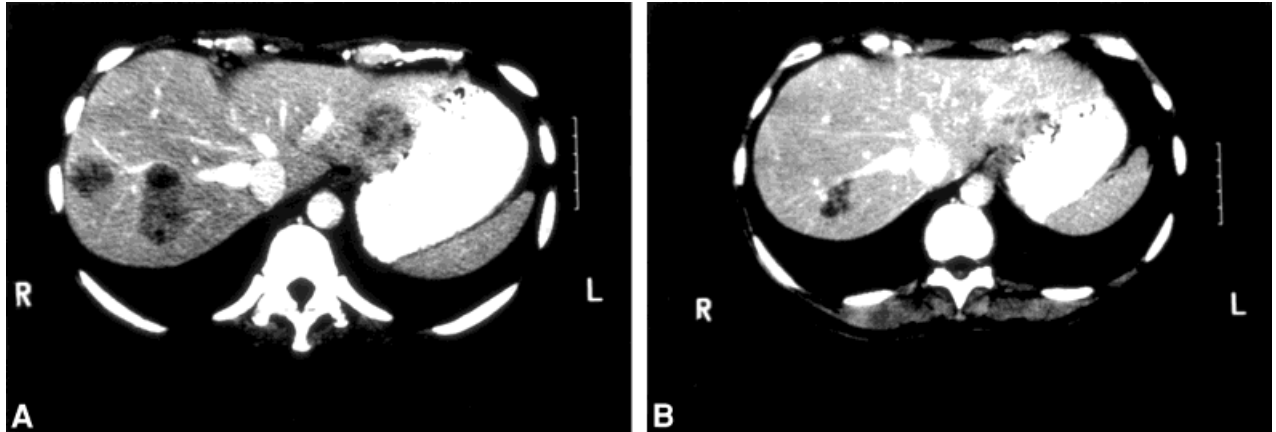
A partial response for Patient 3 is represented. (A) Before: Computed tomography (CT) shows liver metastases prior to the start of chemotherapy. (B) After: CT following four cycles of paclitaxel and tamoxifen shows a decrease in the size of the liver metastases.
